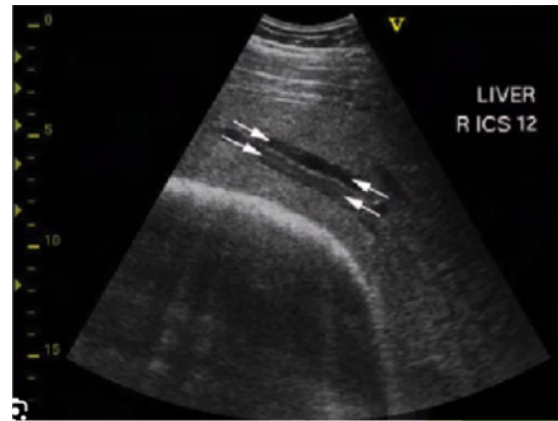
Doppler ultrasonography showing the parallel channel sign indicating intrahepatic dilation
